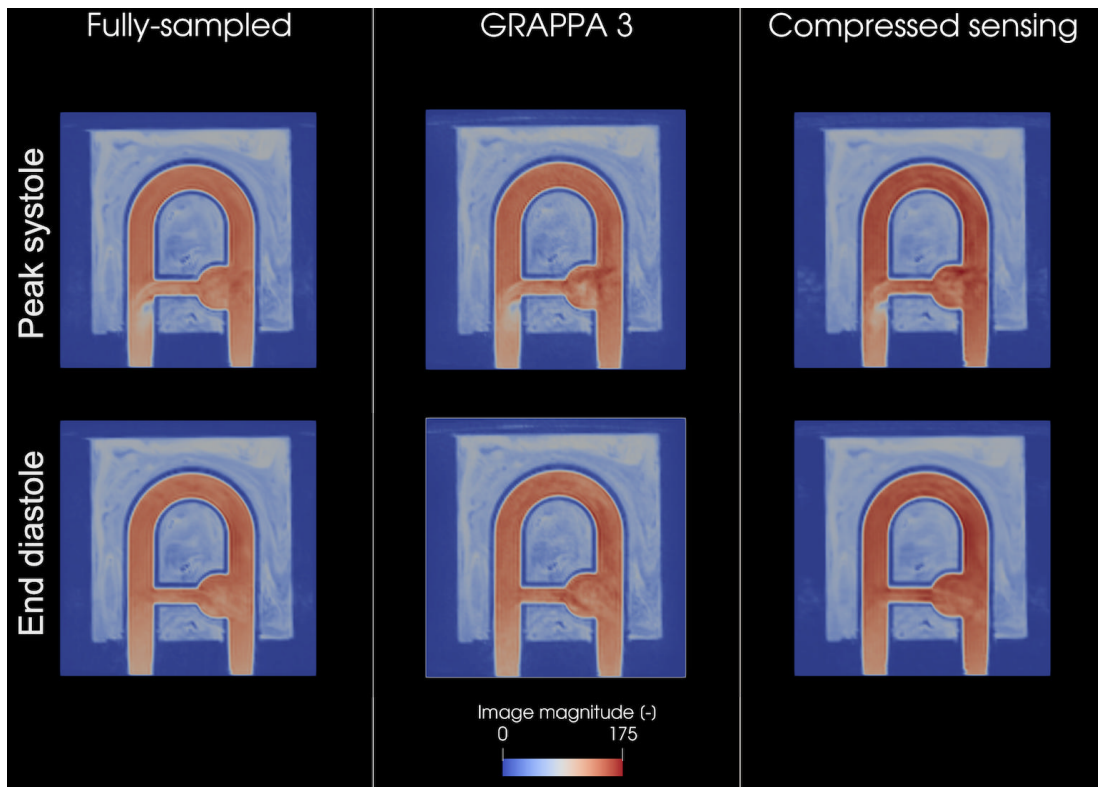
Image magnitude before any correction at peak systole (above) and end diastole (below) for the FS, G3 and CS 4D flow MRI acquisitions.
